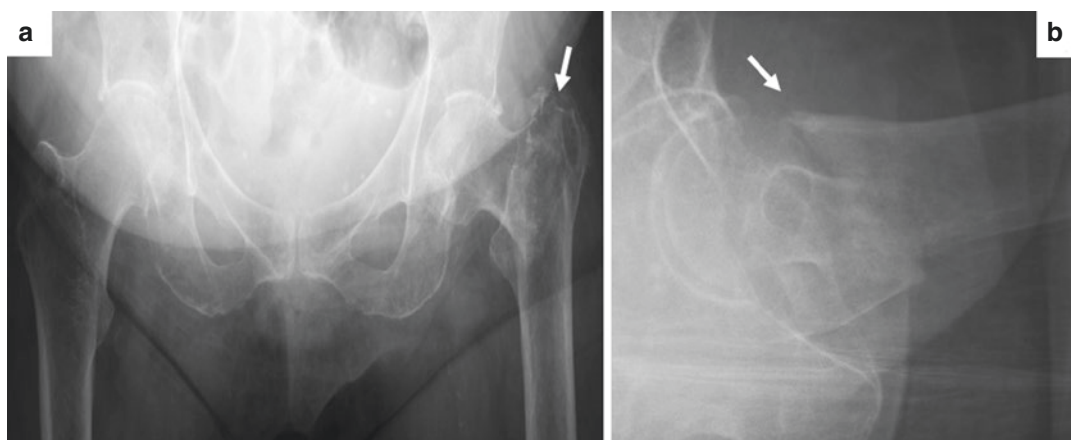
(a) AP pelvis and (b) lateral left hip radiograph demonstrating (arrows) an intertrochanteric fracture pattern
